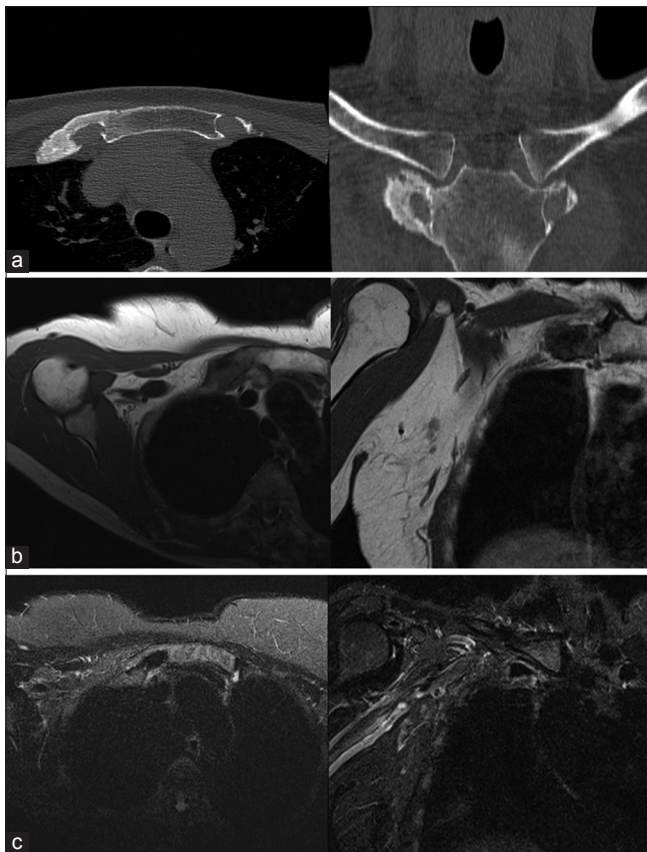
A 52-year-old female presented with anterior chest pain. (a) Selected computed tomography (CT) bony reformats of the upper thorax in the axial and coronal planes demonstrates sclerosis and hyperostosis of the right first sternocostal joint. The sternoclavicular joints are normal. (b) Axial and coronal T1-weighted imaging through the sternum demonstrates low T1 signal centered on the right sternocostal joint, corresponding to the sclerosis and hyperostosis seen on the preceding CT [Figure 1a]. (c) Axial and coronal short-tau inversion recovery weighted magnetic resonance imaging through the sternum demonstrates low-grade bone marrow edematous change related to the right sternocostal joint. Imaging confirmed the final diagnosis of isolated sternocostal hyperostosis/synovitis, acne, pustulosis, hyperostosis, and osteitis.
